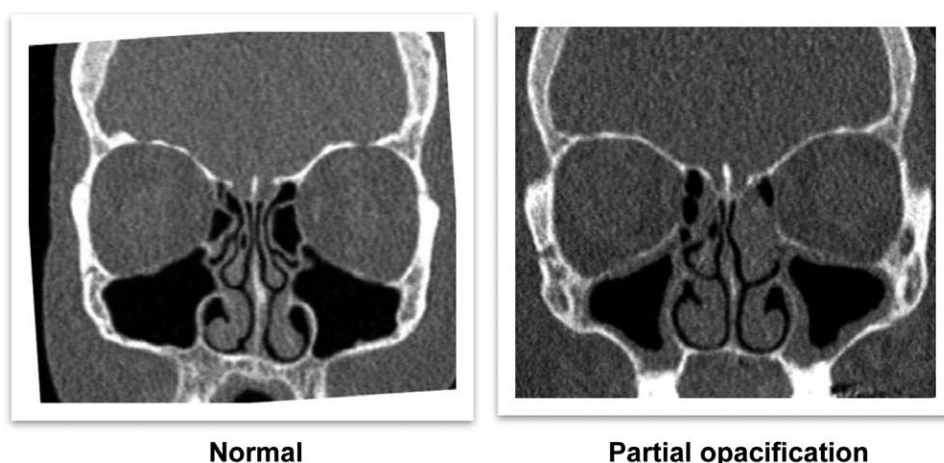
Coronal section of sinus computed tomography scan showing normal (left) and partial opacification of the maxillary and ethmoid sinuses (right) in two individuals from the Geisinger Health System.
